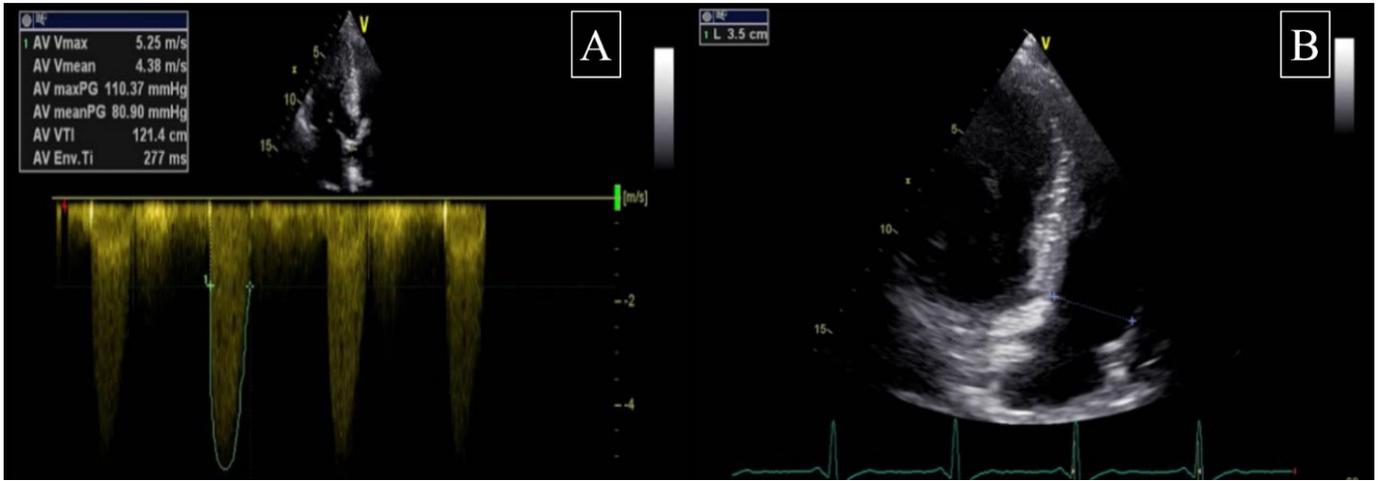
A. Aortic valve gradient on the echocardiography B. Right ventricular size on the echocardiography
